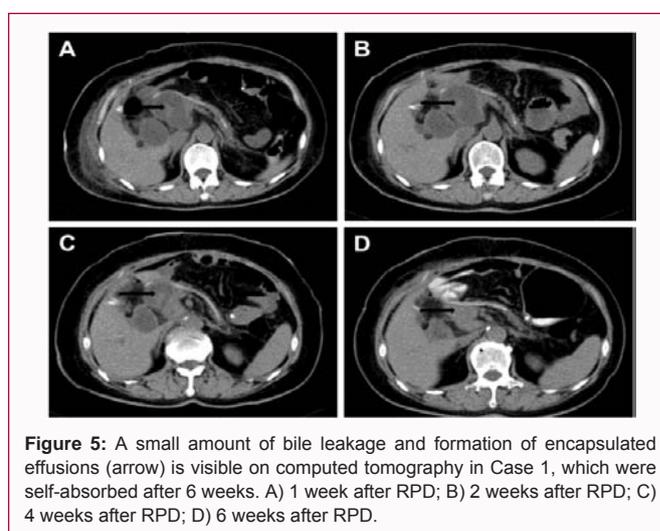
A small amount of bile leakage and formation of encapsulated effusions (arrow) is visible on computed tomography in Case 1, which were self-absorbed after 6 weeks. A) 1 week after RPD; B) 2 weeks after RPD; C) 4 weeks after RPD; D) 6 weeks after RPD.
